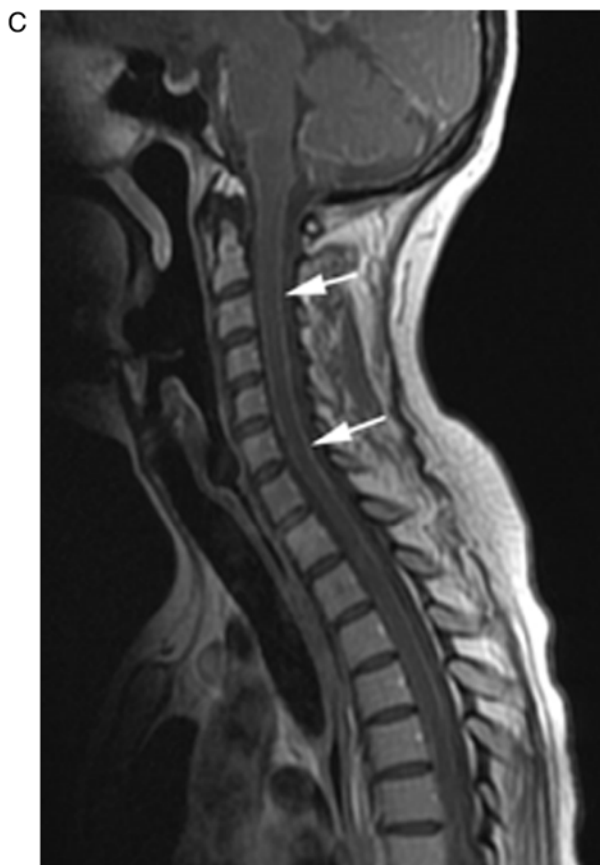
FDG PET/CT scan of a patient diagnosed with neurobrucellosis. (A) Sagittal FDG PET/CT PET maximum intensity projection image of the cervical spine showing diffuse and heterogeneous FDG uptake in the spinal cord (arrows). (B) Sagittal short-TI inversion recovery MRI of the cervical cord showing leptomeningeal hypointensity and thickening (arrows). (C) Sagittal post-gadolinium T1-weighted image showing diffuse leptomeningeal enhancement and thickening (arrows). FDG, fluorodeoxyglucose; PET, positron emission tomography.
